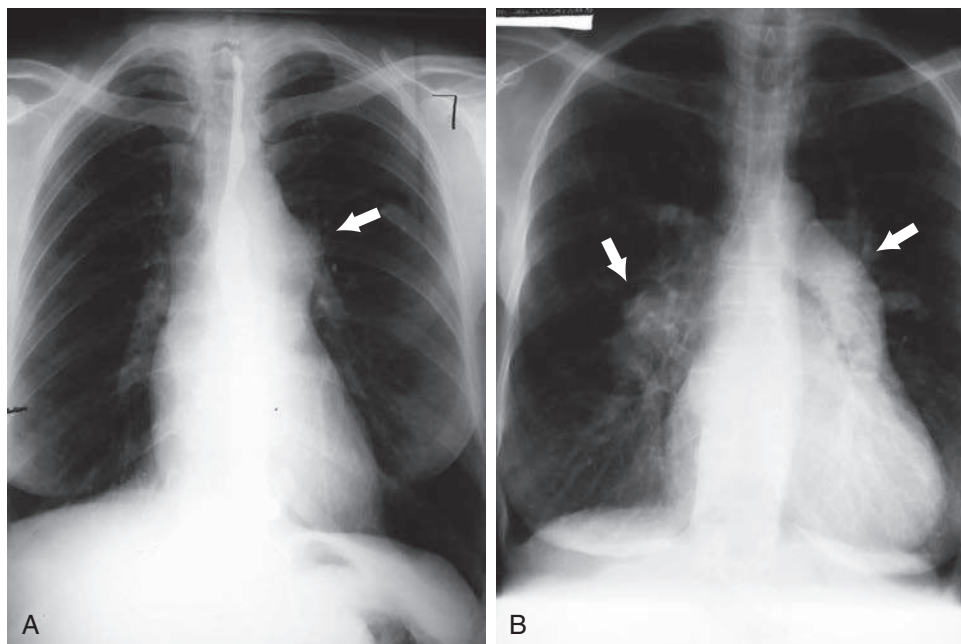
A, Chest radiograph of a patient with pulmonary stenosis. Arrow pointing to a dilated main pulmonary artery. B, Chest radiograph of a patient with Eisenmenger syndrome. Arrow pointing to dilated left pulmonary artery and right pulmonary artery with diminished peripheral pulmonary vasculature.
